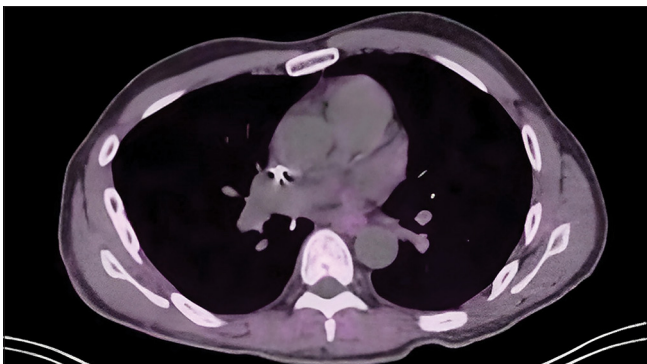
Six-month post-treatment axial contrast-enhanced computed tomography image shows no residual or recurrent subcarinal paraganglioma and an intact atrial reconstruction site. Due to the patient's known genetic mutation of succinate dehydrogenase C, along with his lifetime risk of multifocal and recurrent disease, ongoing surveillance was recommended, such as ⁶⁸Ga-DOTATATE positron emission tomography-computed tomography and whole-body Magnetic resonance imaging. Genetic counseling was also offered to first-degree relatives.
